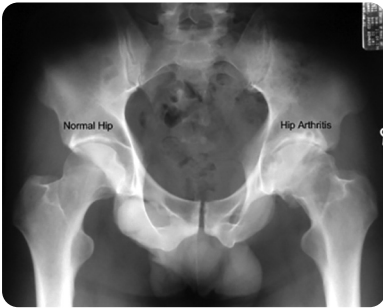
X-ray of an individual with a normal right hip and a left hip with OA demonstrating reduced joint space, subchondral cysts and subchondral sclerosis.
